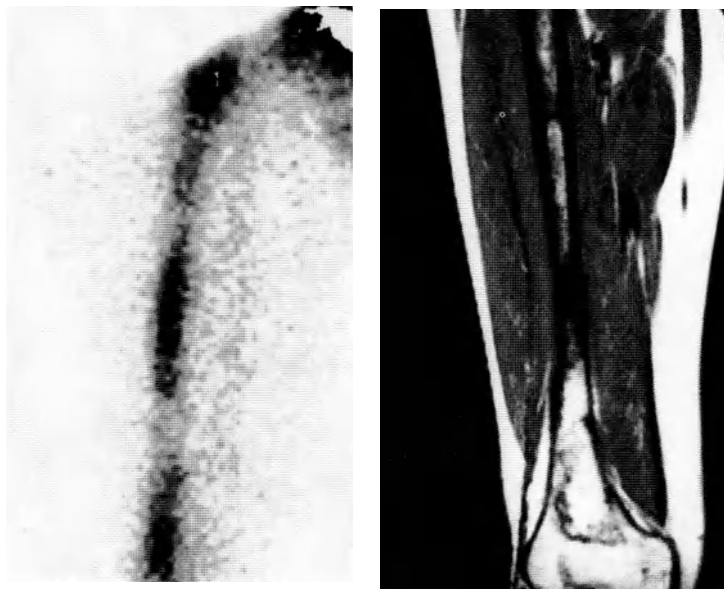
(*left*). Bone marrow scintigraphy: normal findings (class 0)
